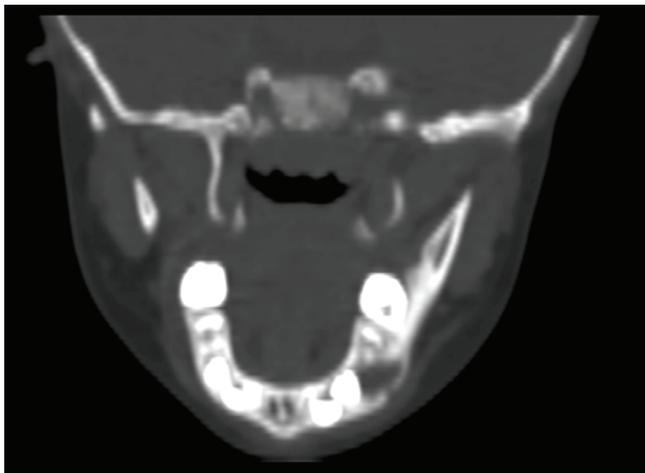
CT scan showing well-defined lytic lesion with cortical plate expansion in left mandibular primary region.
